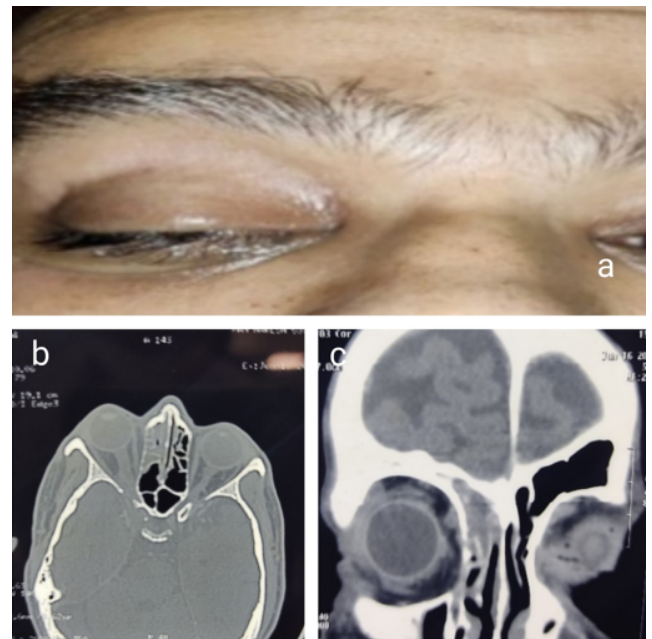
a: Post FESS; b,c: CT of the patient showed Mucosal thickening in right frontal, maxillary and ethmoid sinuses with obliterated rightosteomeatal complex with central hypodense and central hyperdense area lateral to lateral rectus on right side with displacement of lateral rectus with mild thickening of right optic nerve.
